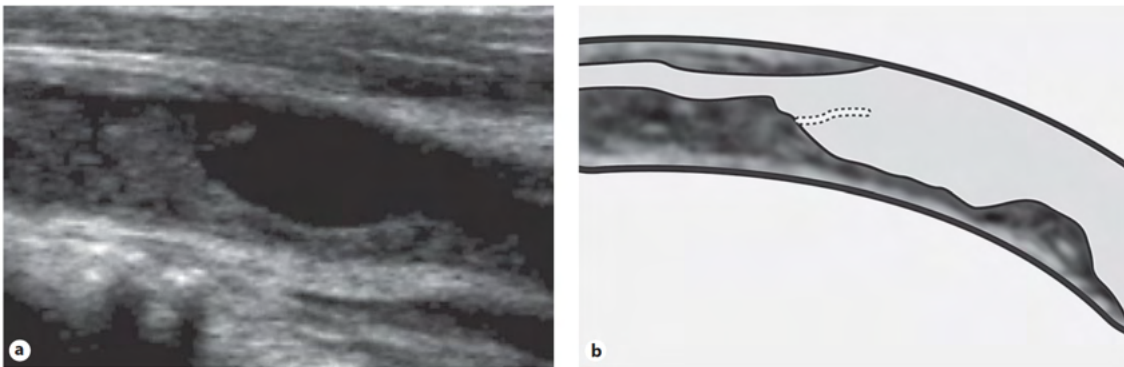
Streaming-band-type seen by supra-aortic trunk ultrasound (A) and its scheme (B) (36).
